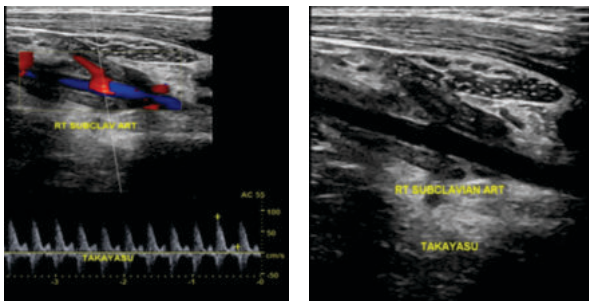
CASE 4: Ultrasound shows involvement of right subclavian artery.
